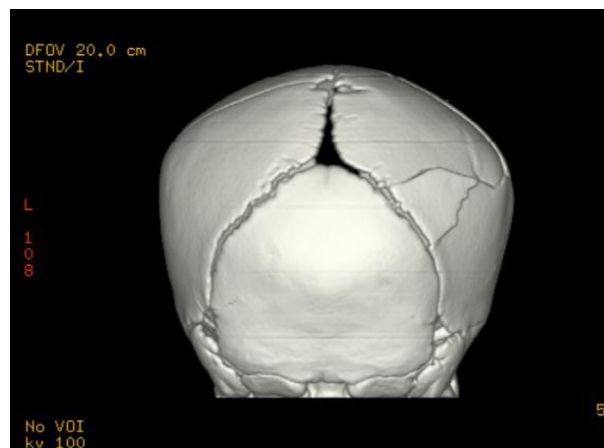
Three-dimensional volume-rendered computed tomography scan showing complex bilateral parietal fractures, more prominent on the right side.
